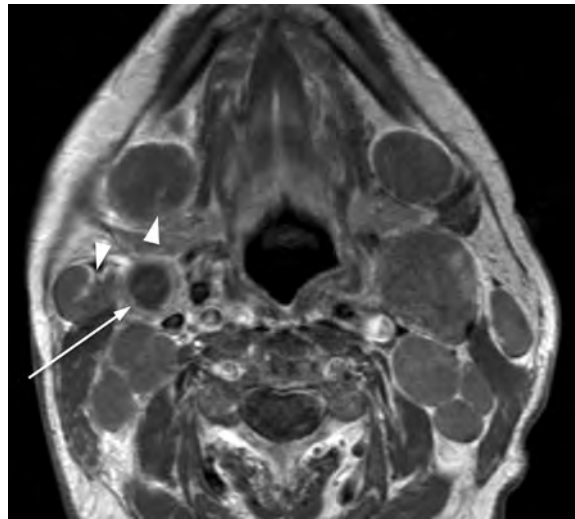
Axial T1 W post contrast MRI showing a typical appearance of nodal lymphoma. There is gross lymphadenopathy with multiple enlarged rounded nodes, most of which appear solid although a right level II node demonstrates necrosis (*arrow*). Hila can be preserved even in grossly enlarged lymphomatous nodes (*arrowheads*)
